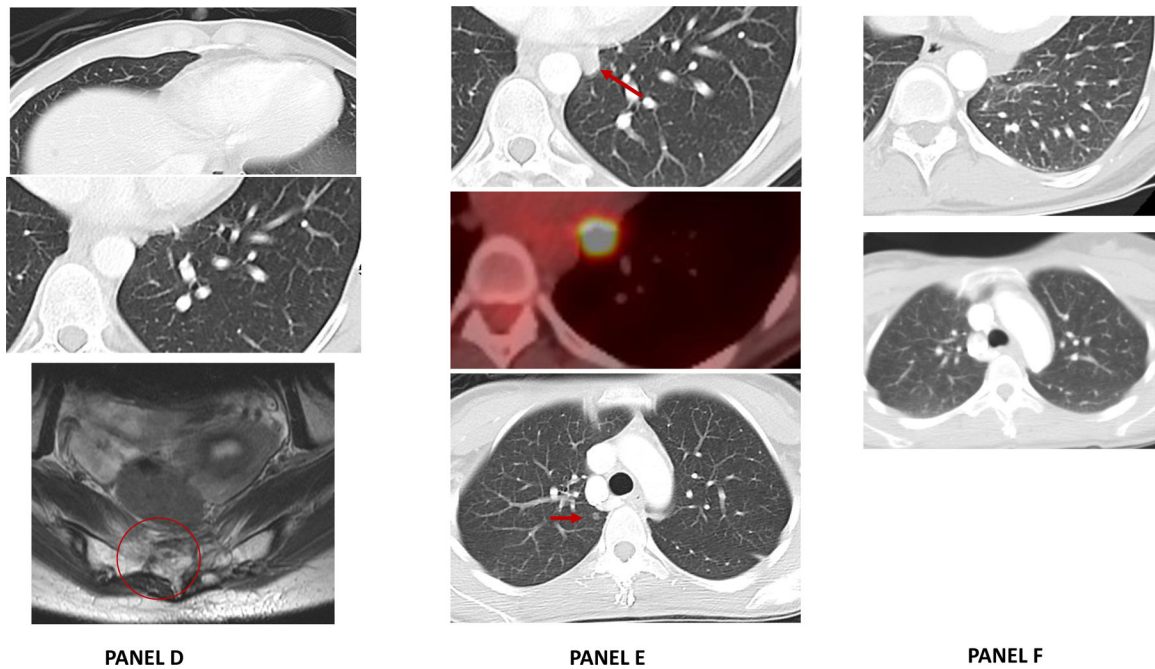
A timeline of events from presentation of symptoms, diagnosis and various treatments. Panel A: Baseline MRI (February 2016) scan demonstrated a 6.4×3.0 cm sacral mass on sagittal T2-weighted images involving S2 – S4 vertebrae, sacral canal and extraosseous involvement of the presacral soft tissues. Staging CT scan demonstrated sub-centimeter mass in the right middle lobe of the lung consistent with metastatic spread.
